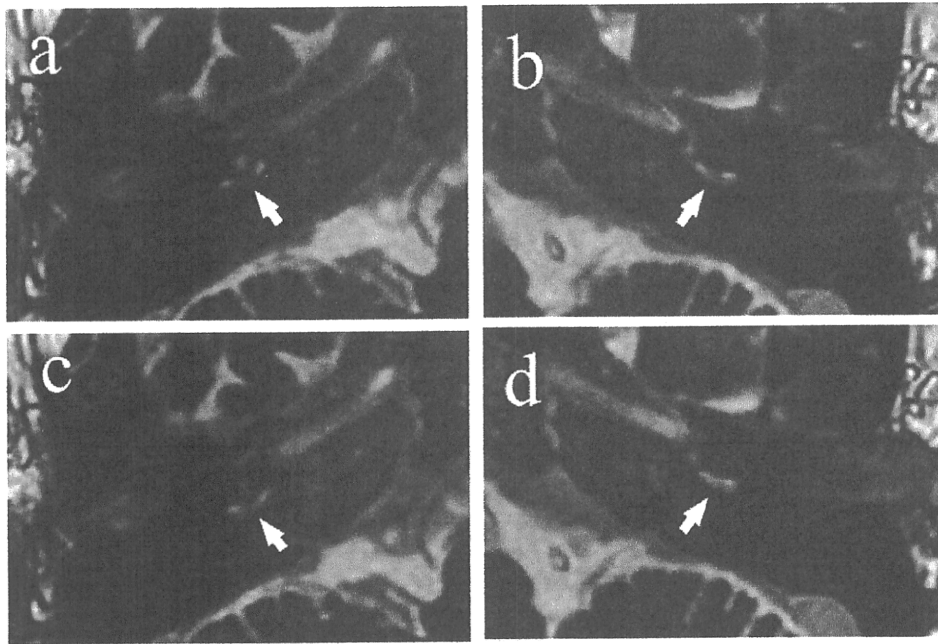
Preoperative 3D fast imaging employing steady state acquisition MRI revealed reduction in fluid intensity in the basal turns in the right (a and c) and left (b and d) ears (arrow). Figure c and d are one slice below than figure a and b.
